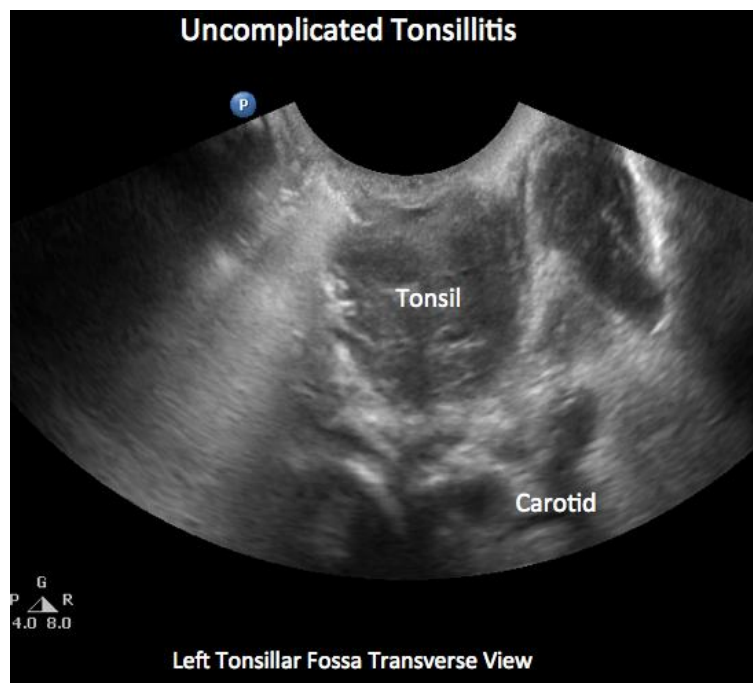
Intraoral ultrasound technique to show the tonsil.
